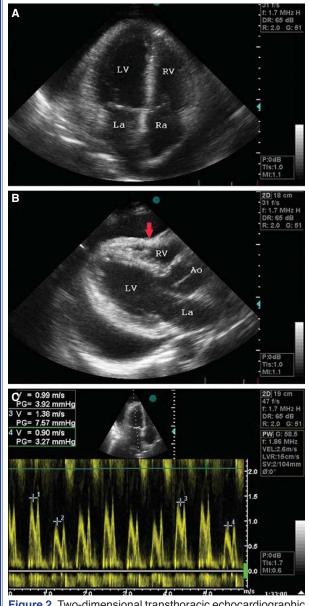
Two-dimensional transthoracic echocardiographic demonstration: (A) Massive pericardial effusion from apical 4-chambers view. (B) Right ventricular diastolic collapse from parasternal long-axis view (arrow). (C) Continuous Wave Doppler revealed significant (37%) respiratory variation of mitral inflow.
